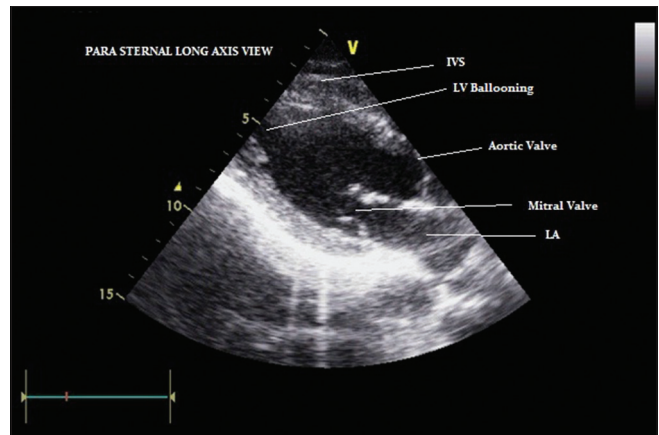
Parasternal long axis view showing apical ballooning
